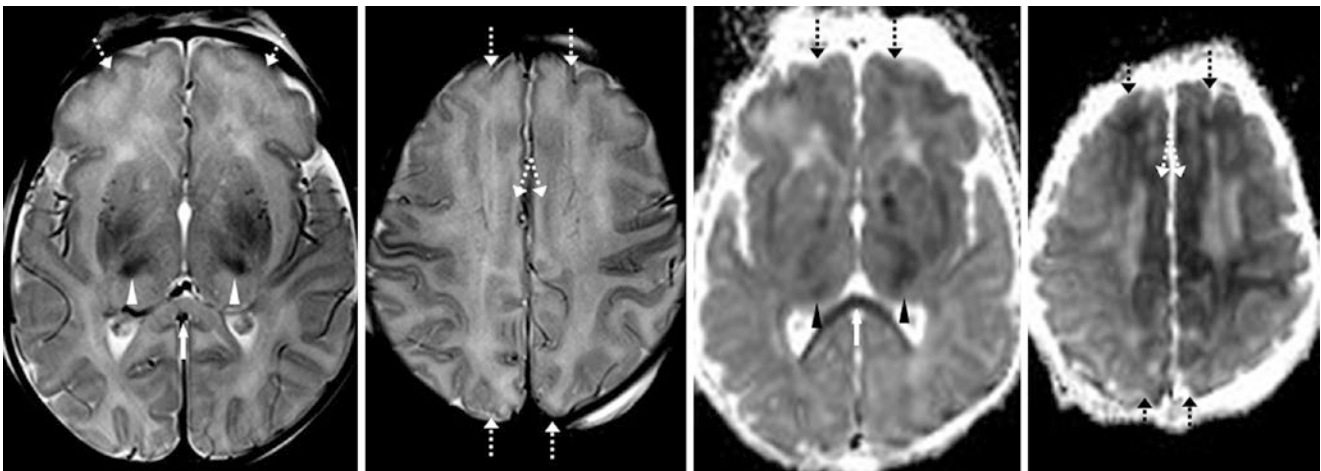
Comparison case of moderate HII. A 2-day-old term neonate delivered after fetal distress had a 3T MRI. SE T2WIs (*left and left middle*) demonstrated a normal, thin PLIC and basal ganglia, but the normal, T2-dark cortical “ribbon” was missing in several locations
